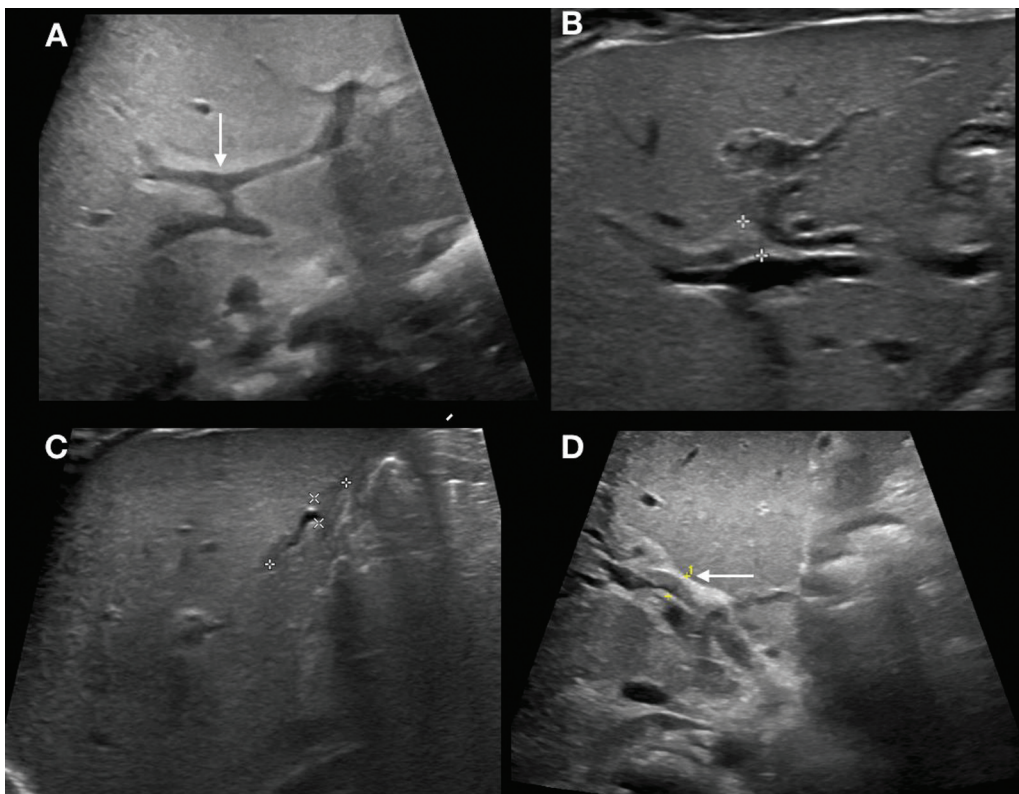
Infant presented with clay colored stools and jaundice. Ultrasonography (USG) showing increased echogenicity anterior to portal vein division (arrow in A and calipers in B). Abnormal gallbladder shape calipers in (C) and increased diameter of hepatic artery 2.2 mm (calipers) in (D). Findings suggestive of biliary atresia.
